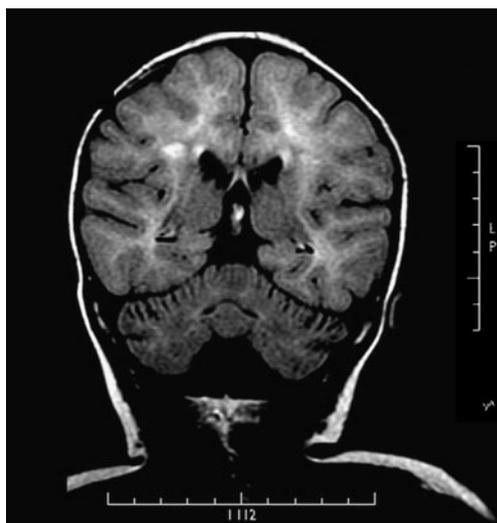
FLAIR (8202/189/2000) Coronal image. Diffuse hyperintensity of the white matter. A focal area of even higher signal was identified close to the right ventricle. Enlarged folia of the cerebellar hemispheres and mild atrophy of the vermis were also observed
